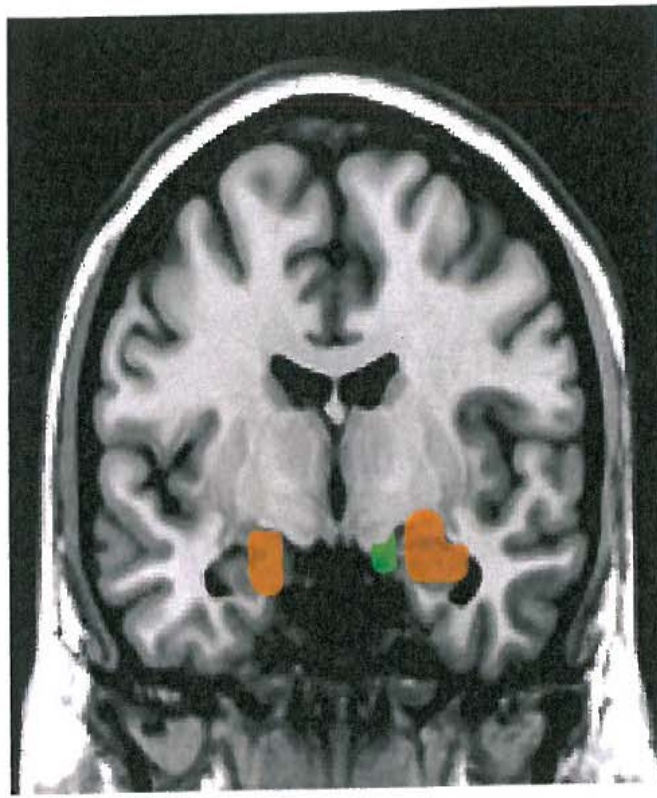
Combined results from two functional magnetic resonance imaging studies in normal subjects in which emotionally arousing images were presented extremely briefly prior to a longer presentation of a neutral image, resulting in masking of the briefly presented images. Although the subjects had no conscious awareness of the masked images, the amygdala was activated by both fearful faces² (gold) and angry faces³ (green), but not by happy or neutral faces.
